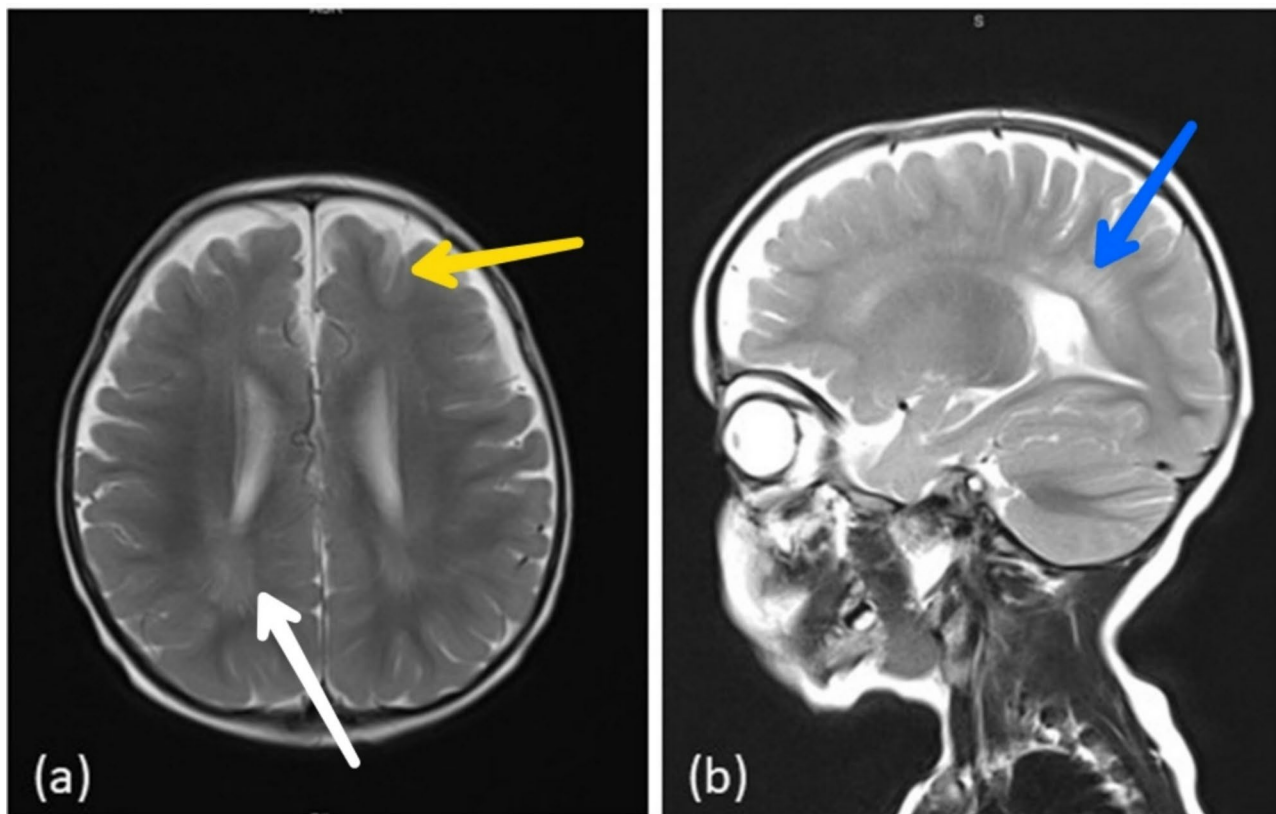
Axial (a) and sagittal (b) T2-weighted MRI images demonstrating faint, confluent high signal intensities in the periventricular and deep white matter, predominantly affecting the bilateral posterior periventricular regions (white arrow), with relative sparing of the subcortical U fibers (yellow arrow). Milder involvement is noted in the anterior periventricular region (blue arrow)
